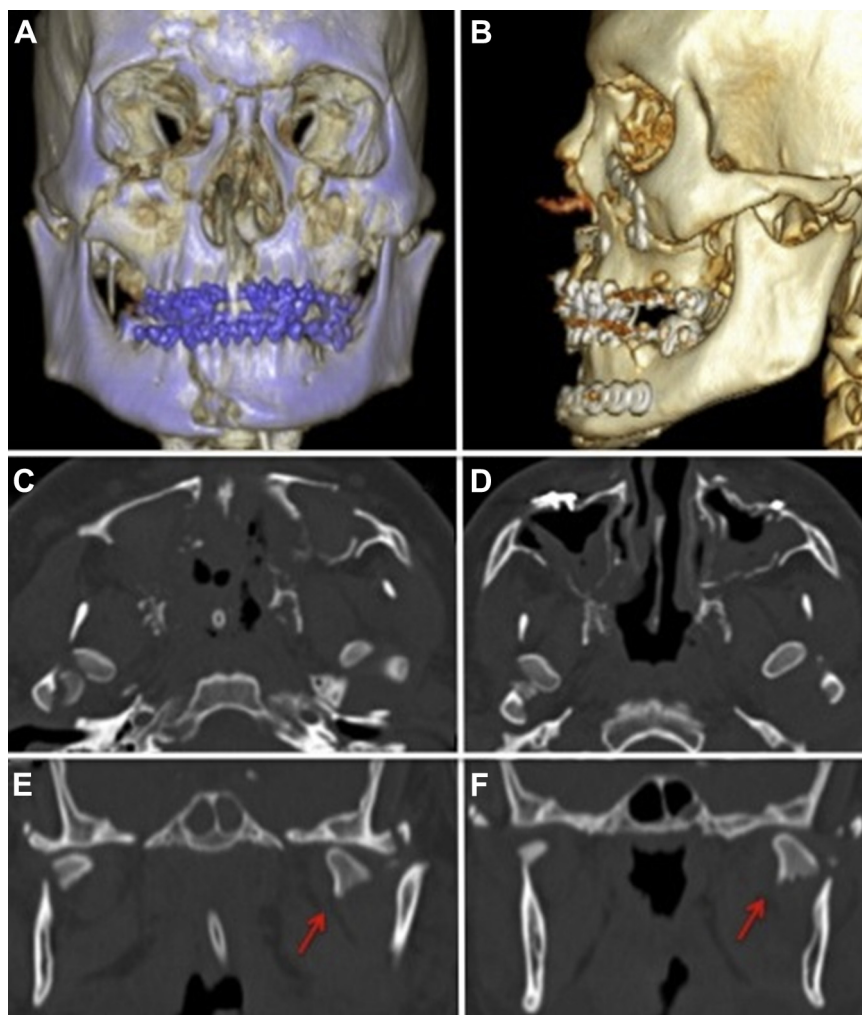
Pre- and postoperative treatment computed tomography (CT). 3-D CT reconstruction after primary treatment with Erich bars (A). Panfacial fracture involving Le Fort I/II and Lanelong maxillary fractures, naso-orbito-ethmoid fracture, parasymphysis, and bilateral mandibular condylar fractures causing facial enlargement. Postoperative 3-D reconstruction after open reduction and internal fixation of fractures (B). Left condyle fracture was treated with closed reduction. Axial CT cuts show high bilateral condylar fracture before (C) and after (D) closed reduction. Left condyle presents a sharp edge in its medial side (E and F, red arrows). This sharp edge could be responsible for the external carotid artery injury.
